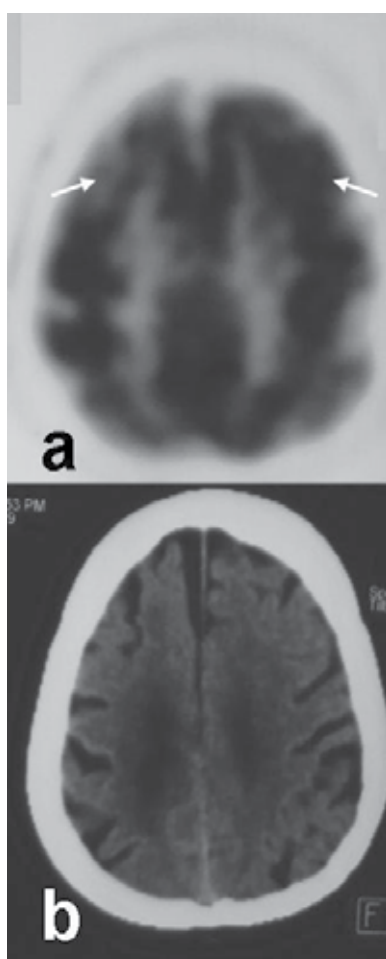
PET (a) and related CT (b) sections of a case with Alzheimer's disease. There were lots of corticosubcortical asymmetrical FDG uptake areas (arrows) show "the hypoactivity" which is in harmonious with the clinical examination findings.
